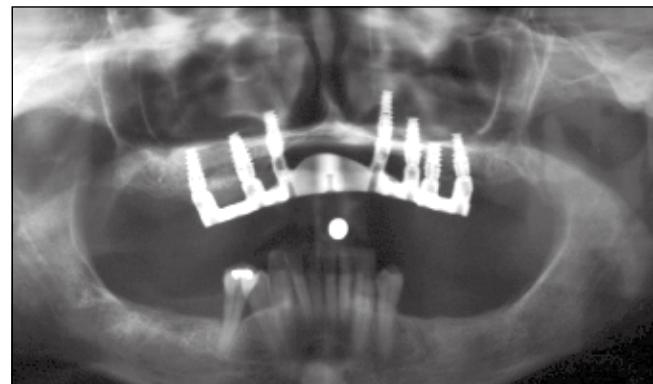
A radiograph of the CAD/CAM-milled titanium bar after fixation to 7 dental implants.
